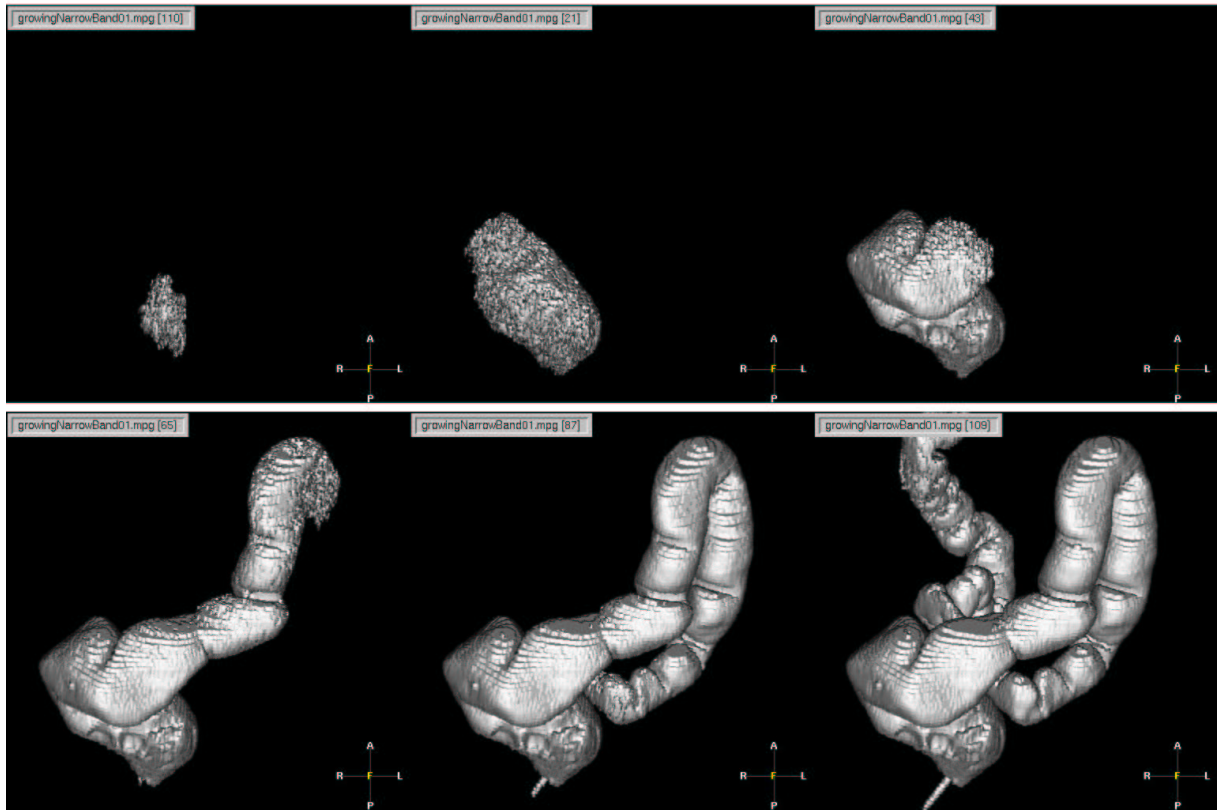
Propagating front inside the colon (original CT data displayed in figure 1).
